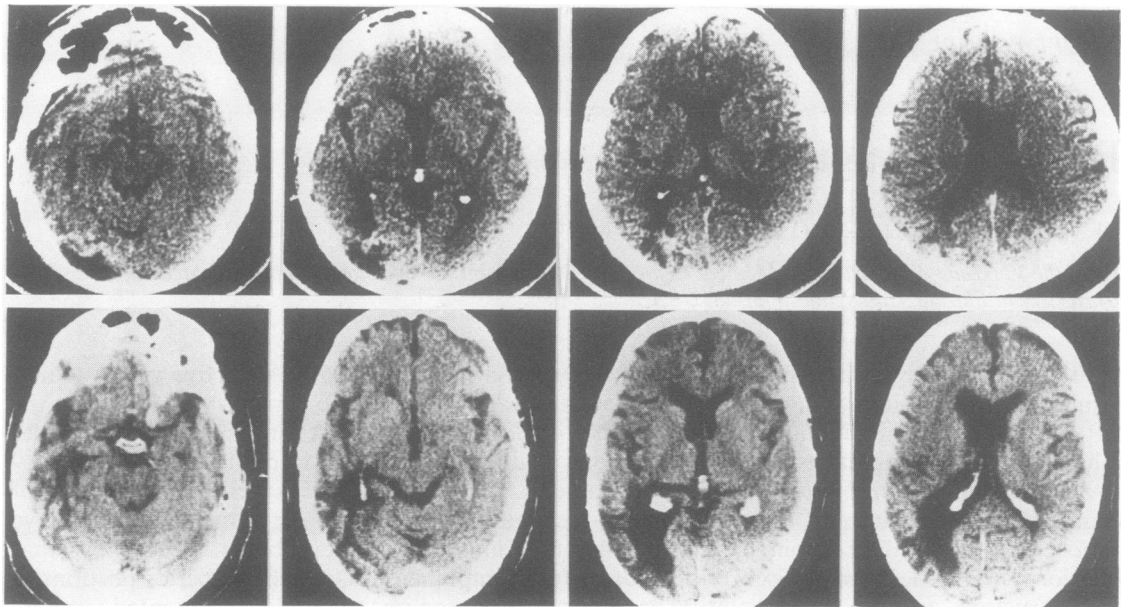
Fig CT scan. Top four views are from patient 1 and bottom four are from patient 2.
